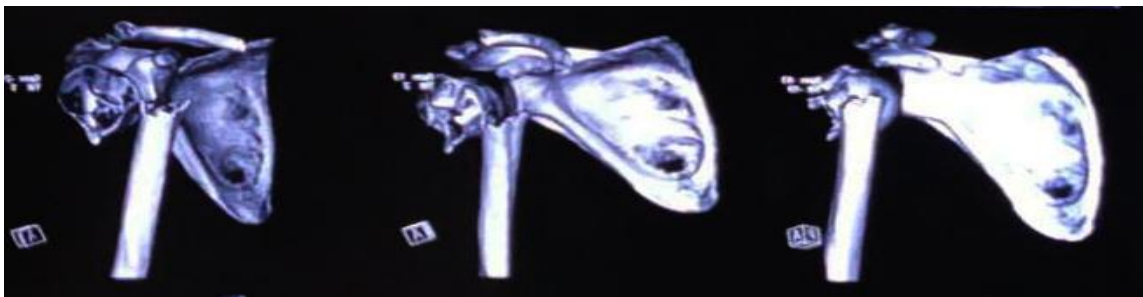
Pre-operative 3-D reconstruction CT scan of proximal humerus fracture
